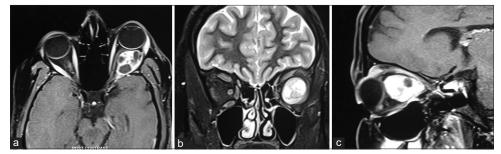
Magnetic resonance imaging of the lesion presenting as oval-to-round solid-cystic mass measuring 2.27 cm × 2.07 cm × 2.69 cm, located between optic nerve and lateral rectus muscle, causing stretching of the muscle and medial deviation of optic nerve; axial (a), coronal (b) and sagittal (c) views
